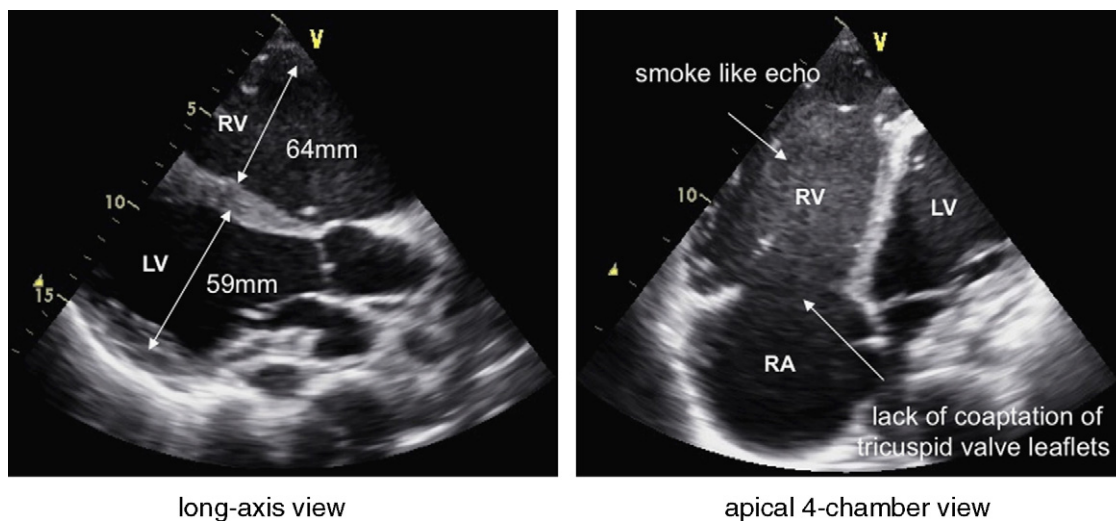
Two-dimensional transthoracic echocardiography showing significant biventricular enlargement. LV, left ventricle; RV, right ventricle; RA, right atrium.
